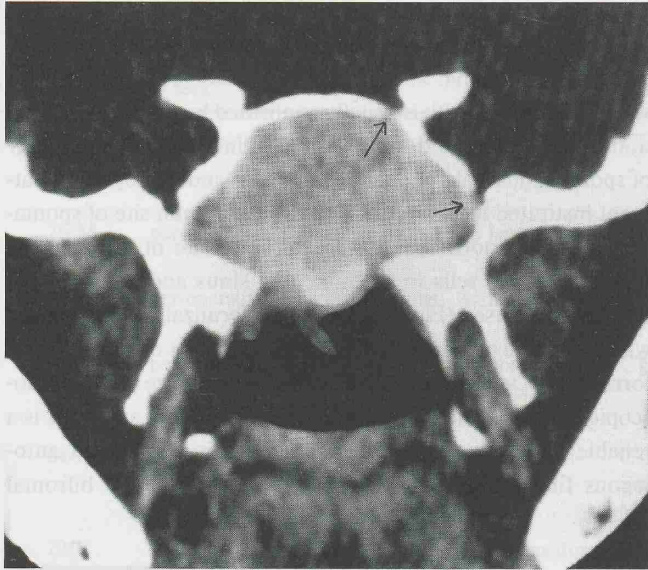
Coronal CT-scan of a sphenoid sinus mucocele with erosion of the roof and lateral wall (arrows).
